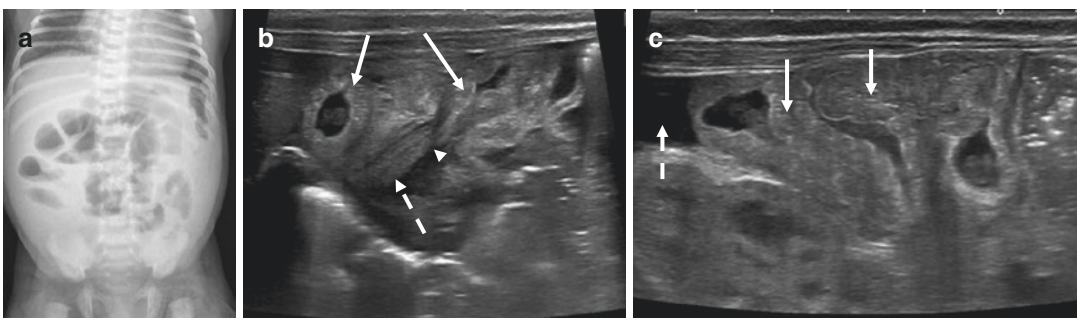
Post-operative adhesion obstruction in a 1-month-old boy with vomiting for 48 h and history of operated congenital diaphragmatic hernia with small bowel placed in the right side and colon on the left side. (a) Upright plain radiograph shows multiple air-fluid levels in the right upper and middle quadrants, with paucity
